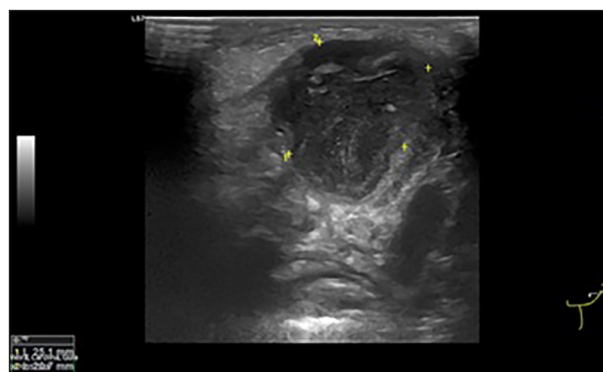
After worsening of inflammatory signs, ultrasound demonstrated echostructural heterogeneity of the parotid glands, with heterogeneous hypoechoic pseudonodular areas in the lower portions bilaterally, with areas of necrosis.
